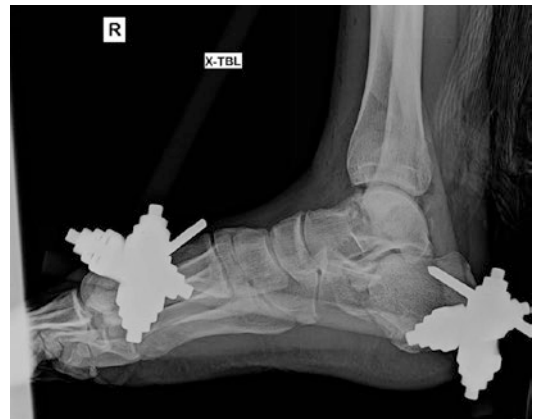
The lateral X-ray demonstrates provisional reduction and medial ankle spanning external fixation of the pilon, talar, neck, and joint depression calcaneus fracture seen in Fig. 22.6a,b
